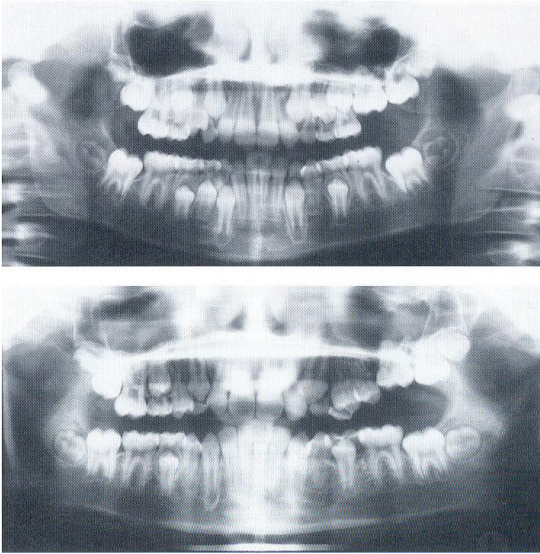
DPT radiographs showing failure of eruption of the upper left first permanent molar
